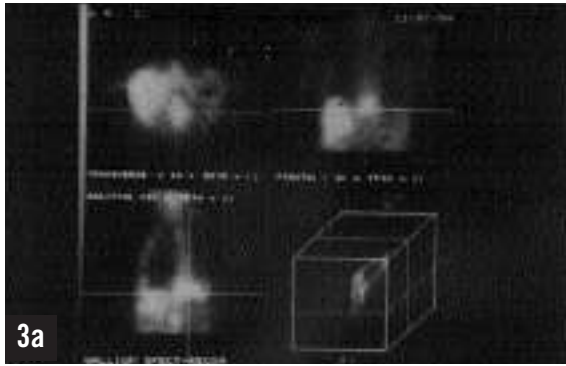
Case 2: scintigraphy (3a) showed abnormal gallium 67 uptake at the level of the tenth dorsal vertebra. Magnetic resonance (3b) of the dorsal spinal cord revealed lymphomatous involvement of the ninth and tenth dorsal vertebrae. Neither vertebral lesion was appreciated by abdominal TC scan (3c), which showed an enlargement of the lomboarctic lymph nodes.
